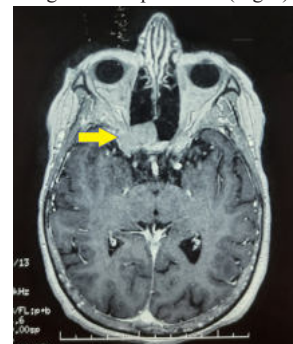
Axial slice of gadolinium-enhanced T1 weight brain magnetic resonance imaging, showing discreetly enhancing tumoral process of sphenoid bone, which extended to right optical channel sheathing the right optic nerve, right cavernous sinus and right left temporal lobe.
